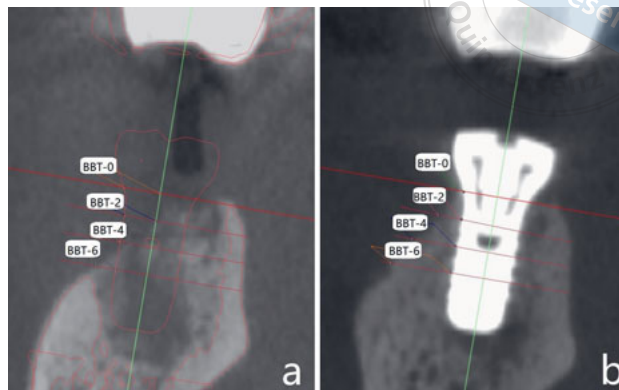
Measurement of the thickness of the buccal bone plate at different levels below the smooth-rough implant interface. (a) Measurement before surgery (registration with the CBCT mandible and implant model immediately after surgery). (b) measurement immediately and 5 months after surgery.
